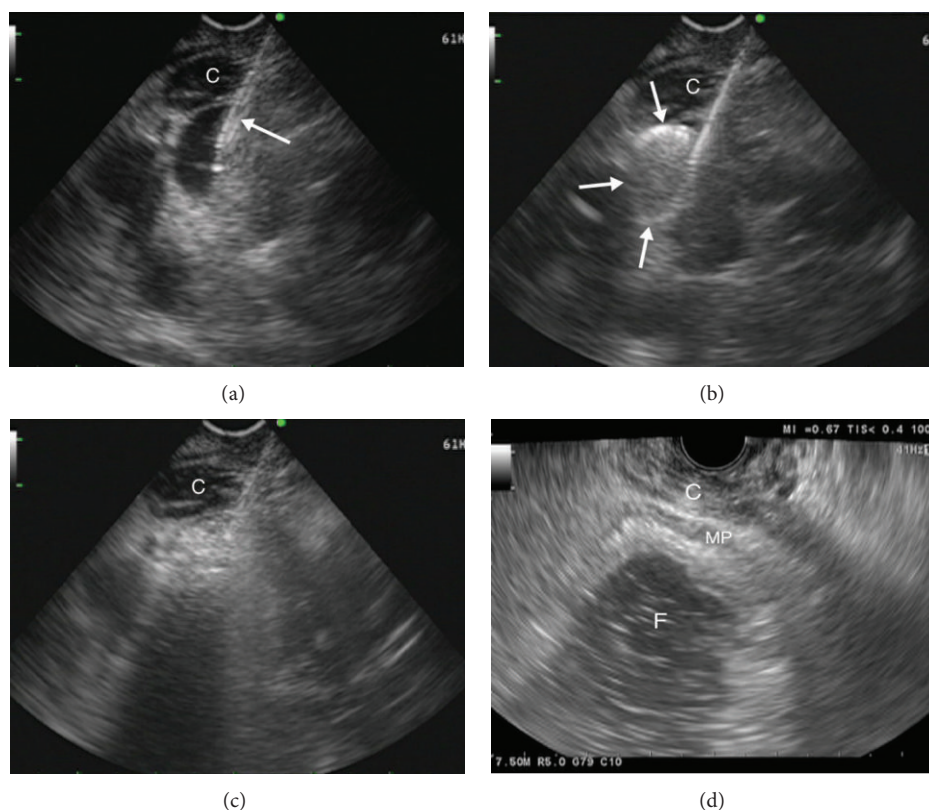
(a) Endosonographic transesophageal view—a 19-gauge needle inserted into the varix (arrow). (b) Coil delivery (arrows) through the 19-gauge needle. (c) Injection of 1 mL of cyanoacrylate. (d) Fundal varices obliterated. C: crus muscle, F: fundus; MP: muscularis propria of stomach wall. (Images courtesy of [32]).
